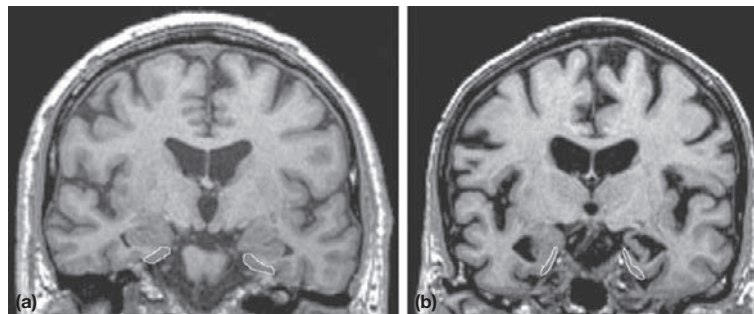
Temporal atrophy with AD. Coronal MRI at the level of the mammillary bodies. The entorhinal cortex has been outlined in a normal control (a) and a person with mild cognitive impairment of the amnesic type (b).
